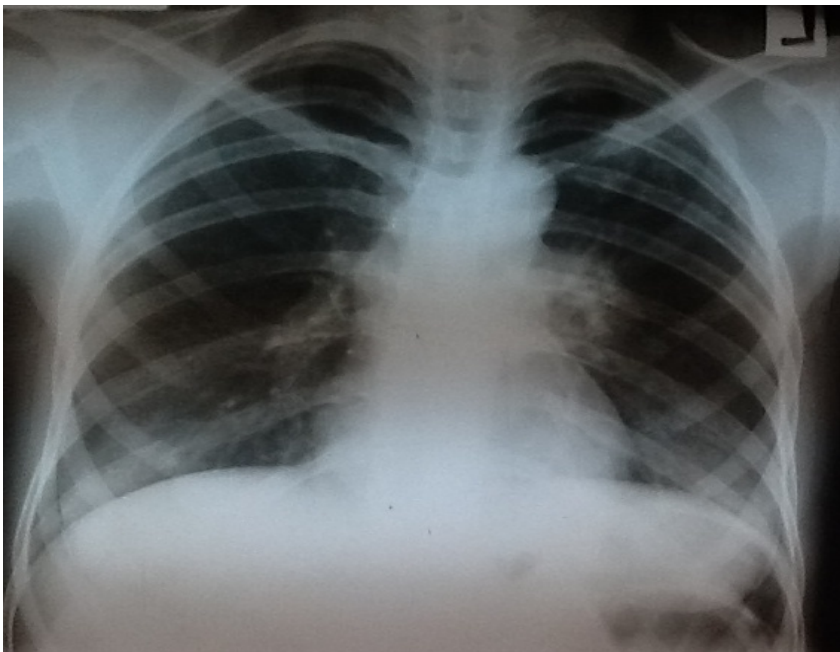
PA chest radiograph of 38 year old patient showing left hilar enlargement (CD4 count = 22cells/ μ l, VL = 32,688 copies/ml).
